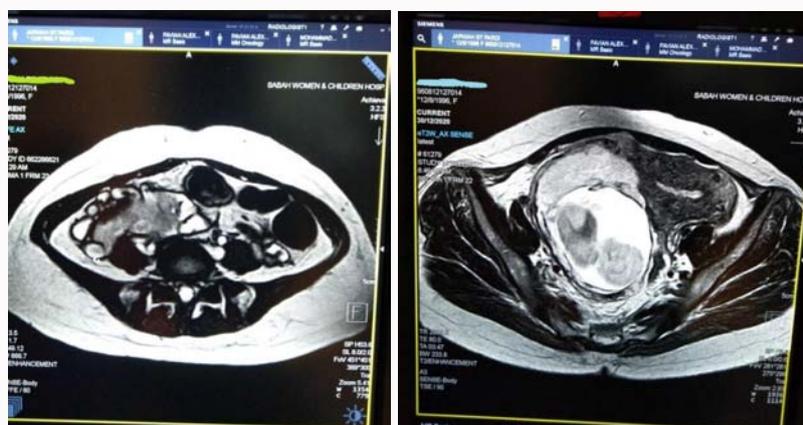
MRI shows an empty uterus and enlarged 5 cm × 6.6 cm 12.4 cm. Presence of singleton fetus within intact T2W hyperintense amniotic cavity in the pelvic cavity outside the uterus. It is located at the right adnexal displacing the uterus to the left side. Placenta is located mainly anteriorly abutting the right fallopian tube and peritoneal surface of the right lateral pelvic and abdominal wall. Left laterally, placenta extends over the right side of uterine wall. Right laterally, placenta compresses over right common iliac vein, however still patent. This placenta extends posteriorly with no extension to the rectum. No evidence of placental implantation on sigmoid. No free fluid and other pelvic structures look normal.
